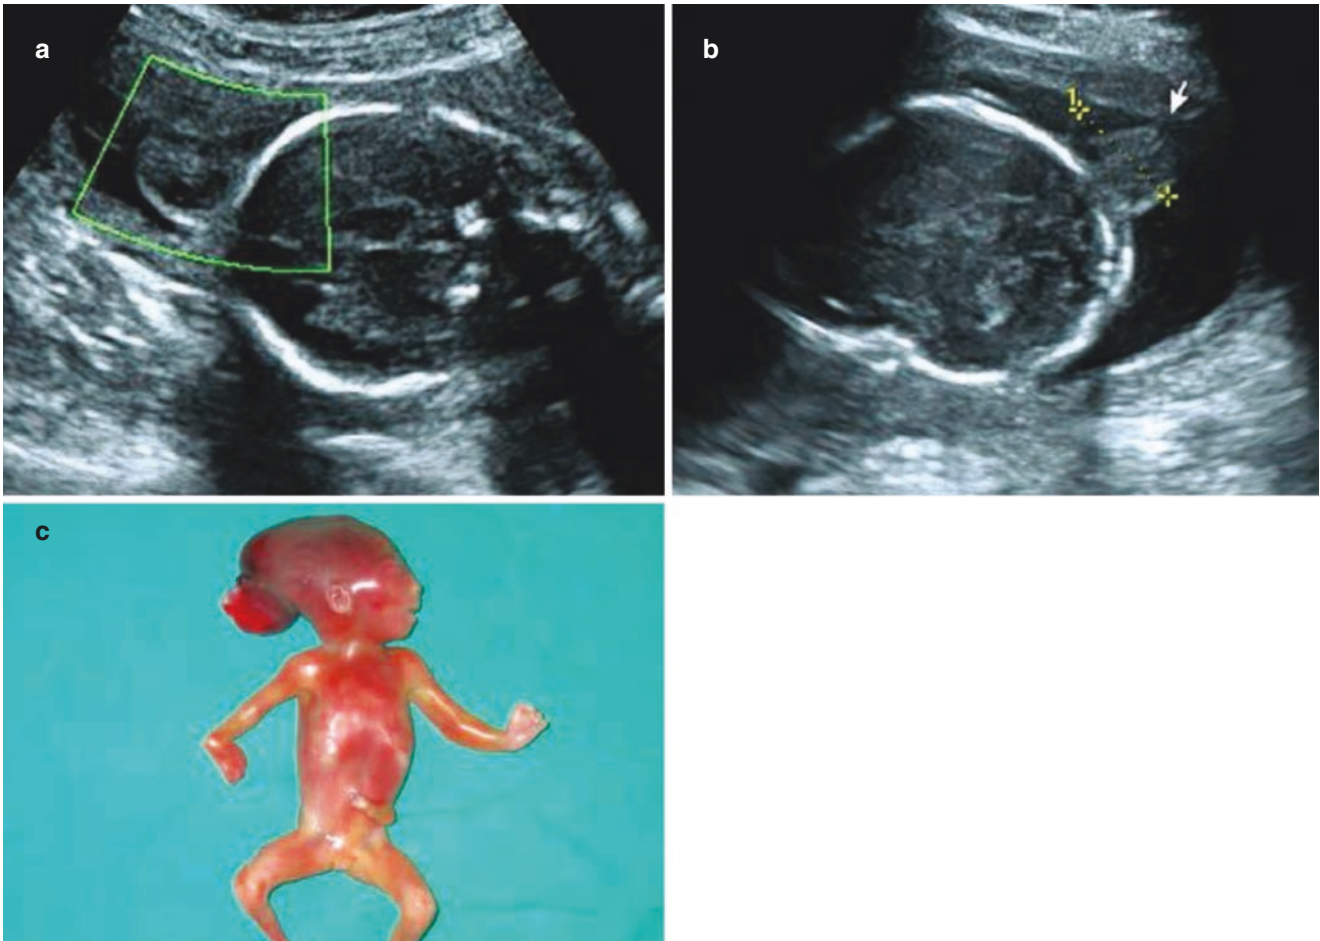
Occiput posterior encephalocele. (a–c). Prenatal ultrasound performance and images of the autopsy
